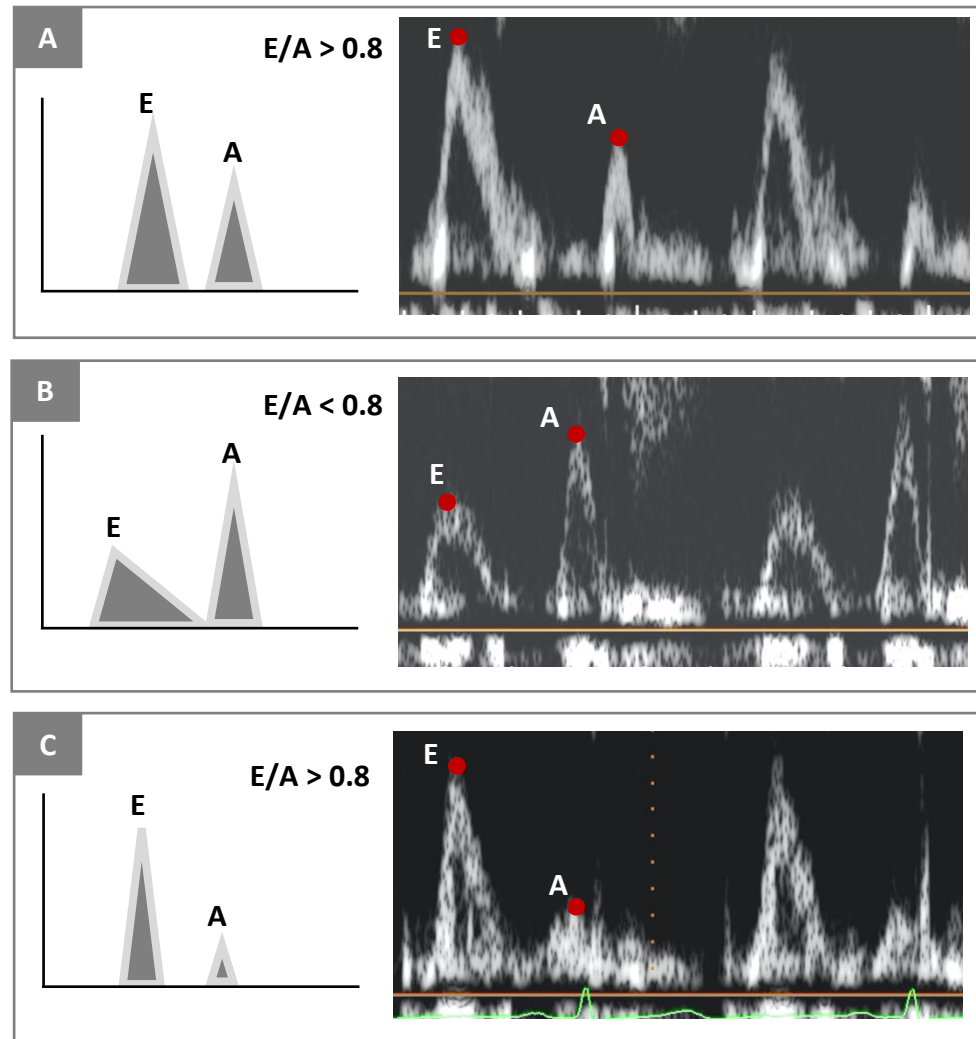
Mitral valve inflow trace using Doppler echocardiography.
